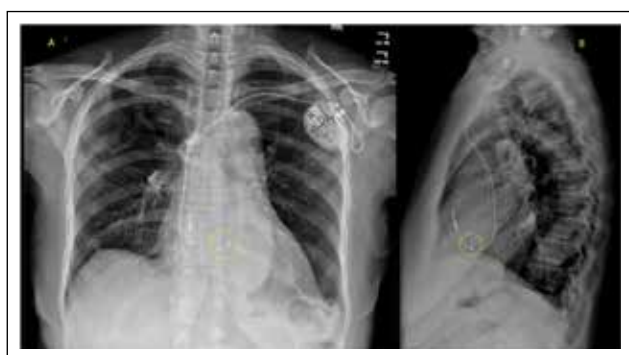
Chest radiographs in frontal and lateral show the typical location of the His bundle lead (dotted circle) (Image courtesy: Chen et.al).³
